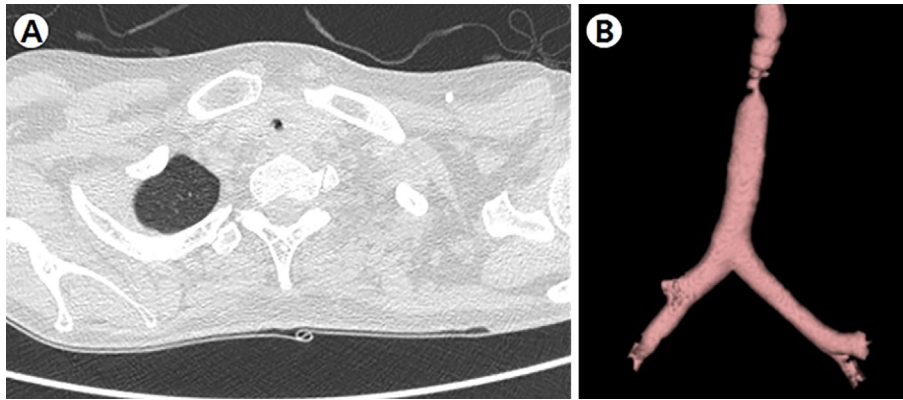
(A, B) Initial tracheal computed tomography shows luminal narrowing of the trachea where the narrowest diameter=3.8 mm.
